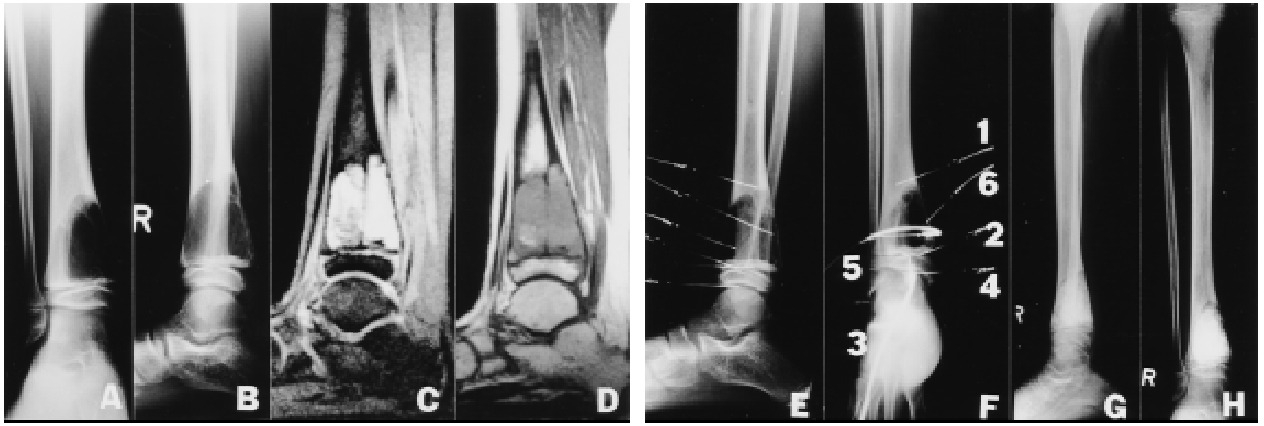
Routine radiographs of an 11-yr.-old boy with aneurysmal bone cyst in the distal tibia, very close to the growthplate (A,B). Magnetic resonance imaging, T2 (C) and T1 (D), showing erosion of the cortex and a fairly homogeneous intensity of the contents of the cyst consistent with fluid. Intraoperative radiographs showing localization of the temperature couples. Number 2 and 3 are situated in the growthplate, number 4 is intra-articular (E,F). The intralesional temperature couple, number 7 was added later. Numbers correspond with those in Figure 3A. After curettage and cryosurgery, the cyst is filled with a homologous bonegraft (G,H).
